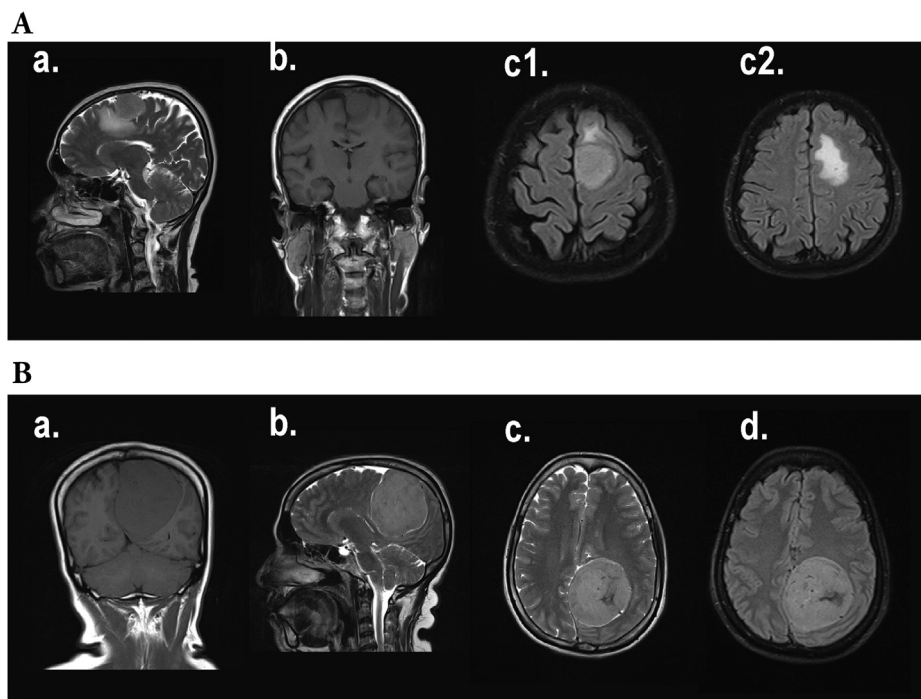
Magnetic resonance images (MR) of meningioma | (A) a. T2W sagittal, b. T1W coronal, c1, c2 FLAIR axial MR images of the brain showing perilesional oedema. In a and c—as T2 and FLAIR hyperintensity surrounding the tumour. b—T1 hypointensity immediately around the tumour; mainly in white matter making finger-like projections in to the white matter of the brain, features are better demonstrated in T2 and FLAIR images than in T1 images. (B) a. T1W coronal, b. T2W sagittal, c. T2W axial, and d. FLAIR axial MR images of the brain showing mass effect. Images demonstrate compression of the adjacent anatomical structures due to pressure effects from the tumour. Falx cerebri is curved and deviated to right side (contralateral side) by the left side tumour. Sulci/gyri on left occipital region posterior to the tumour are also compressed. The posterior aspect of the corpus callosum is depressed by the mass.
